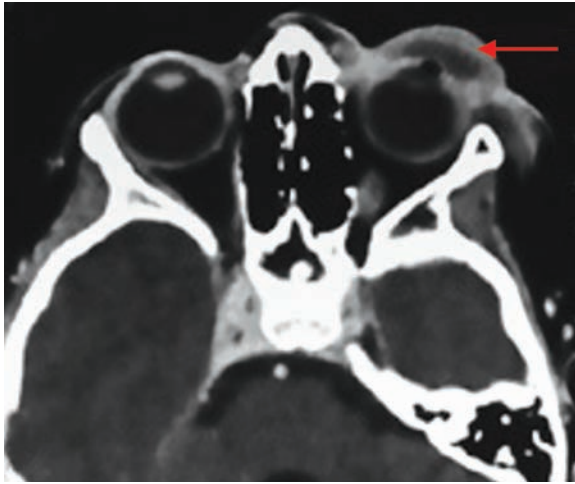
The CT scan of the patient showing the lesion over the left upper eyelid and extending into the temporal region. The lesion also appears to be compressing the eyeball (red arrow showing the lesion)
